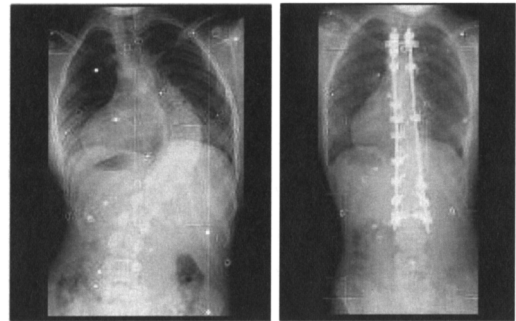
Pre-op and post-operative frontal radiographs of a scoliotic patient with CD Horizon posterior instrumentation.
